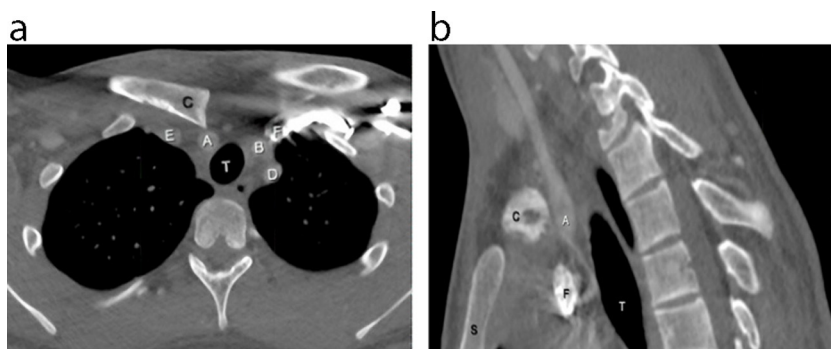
(A) Axial view of the superior chest CT scan showing medial clavicle (C) abutting the brachiocephalic artery (A). Also are shown the trachea (T), left common carotid artery (B), left subclavian artery (D), right and left brachiocephalic vein (E and F). (B) Sagittal view of superior chest CT scan showing the medial end of the right clavicle (C) in contact with the brachiocephalic artery (A). Are also represented the trachea (T), sternum (S) and the left brachiocephalic vein (F).
